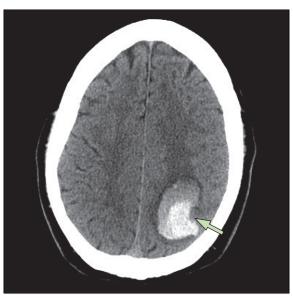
CT of a patient with acute confusional state This patient aged 67 years presented with acute confusion and inattentiveness. He had driven himself to a routine primary-care doctor appointment 2 h earlier. The patient recalled signing in at the physician's office with his name at an angle on the page, but he did not recall being at the office or driving himself home. On returning home, his wife immediately noticed that he was confused and that he was "using incoherent words". She brought him to an emergency department, where this CT was obtained. At the emergency department, he complained of a mild "burning sensation" in his head, but he had no motor or sensory complaints or any abnormal findings on neurological examination. Arrow shows left parietal intracerebral haemorrhage.
